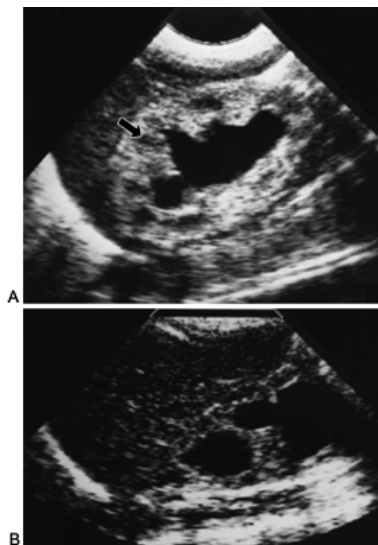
Sonograms of kidneys from infants with posterior urethral valves. A: Corticomedullary junction is present (*arrow*). At birth, creatinine rose to 2.8 mg/dL but fell to 0.6 mg/dL following valve ablation. B: Corticomedullary junction absent. The infant progressed to chronic renal failure.
